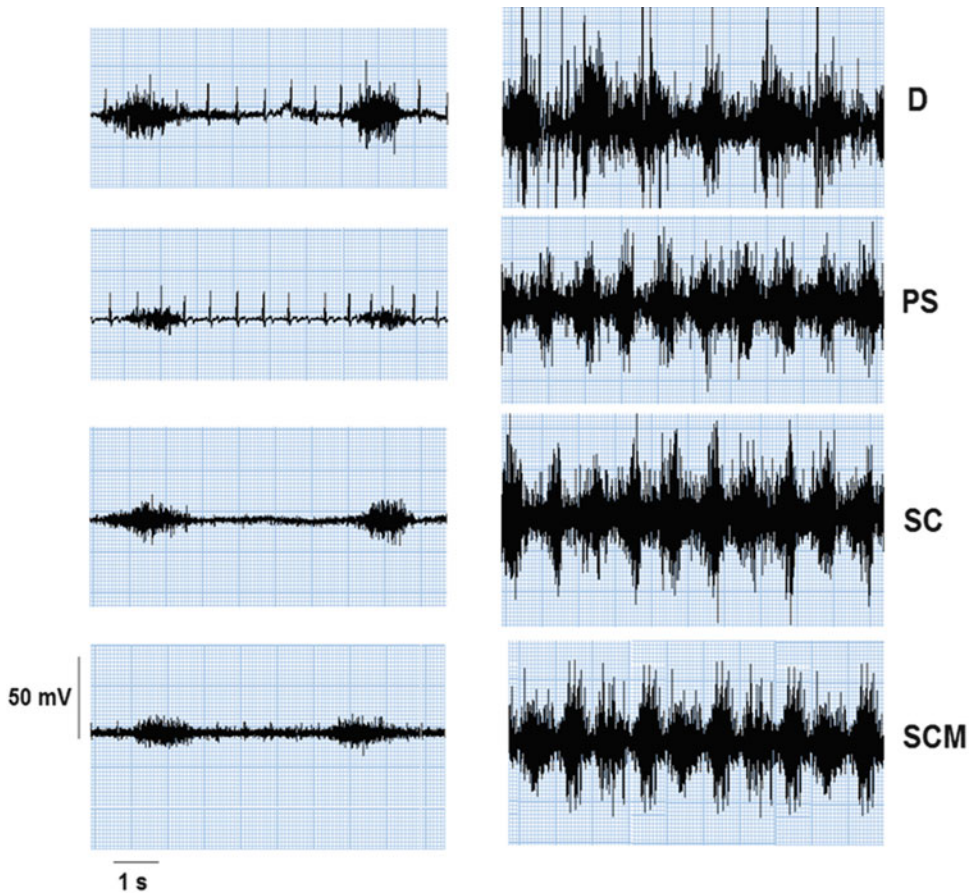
Typical EMG recordings of the diaphragm (*D*), intercostal parasternal (*PS*), sternocleidomastoid (*SM*), and scalene (*SC*) muscles before exercise and during peak-exercise
